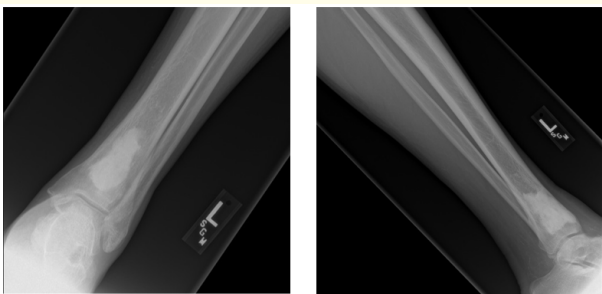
Postoperative AP/lateral x-rays: Final follow-up x-rays AP and lateral of the ankle shows progressive incorporation of the bone graft without radiolucency to suggest recurrence of the infection.
